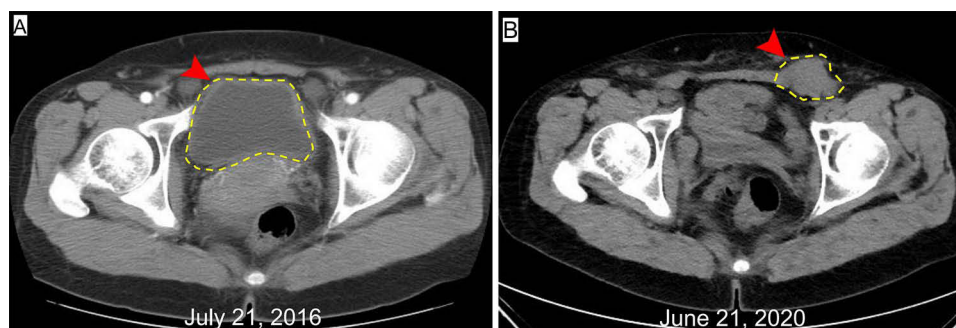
Pelvic computed tomography (CT) results of the patient in Case I at the time of initial treatment and recurrence. (A) CT revealed a mass (13.0 cm × 6.0 cm × 3.8 cm) in the right adnexa (red arrow and yellow outline) on July 21, 2016. The boundary between the mass and uterus was clear. A liquid density shadow could be seen in the pelvic cavity. No enlarged lymph node shadow was found in the retroperitoneum or pelvic wall; (B) CT showed a nodule (3.2 cm × 3.2 cm) in the left inguinal region (red arrow and yellow outline) on June 31, 2022.
